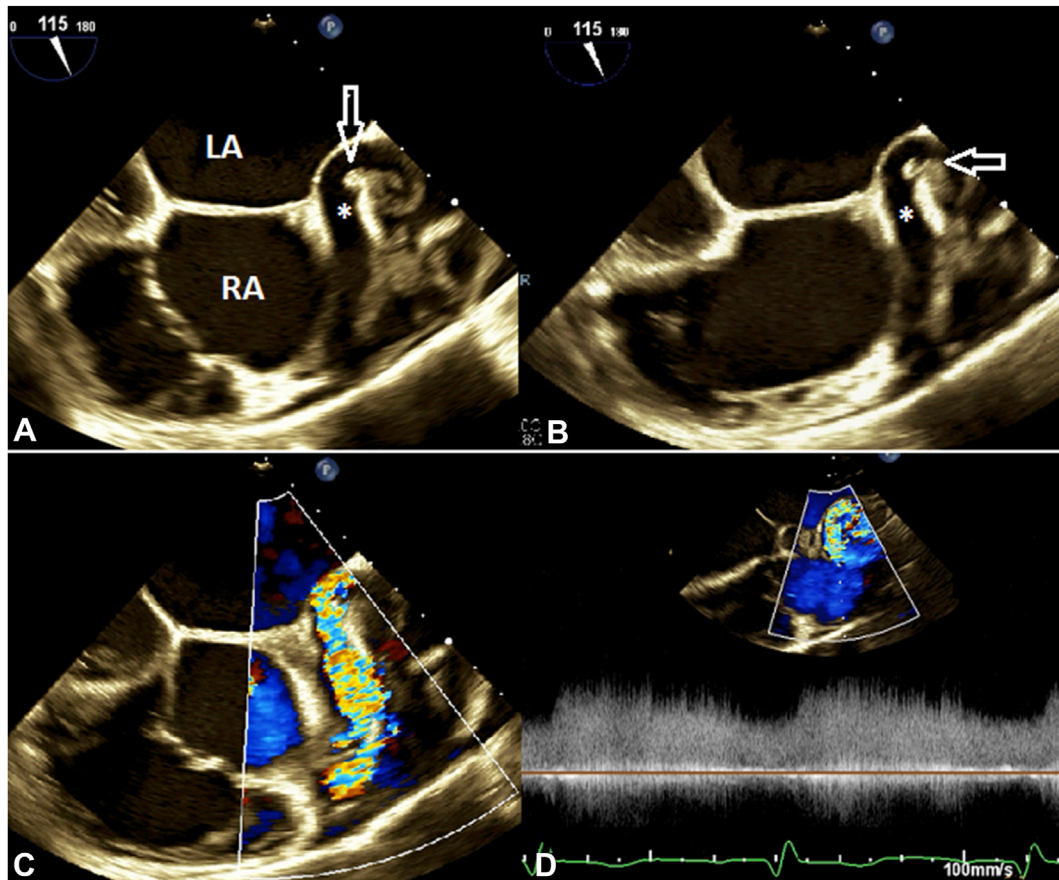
TEE, midesophageal long-axis (115°) systolic (A) and diastolic (B) views without (A,B) and with (C,D) color flow Doppler, including pulsed-wave spectral display (D), demonstrates the CAF (asterisk), the vegetation within the CAF (arrow), and turbulent, continuous flow within the CAF.
